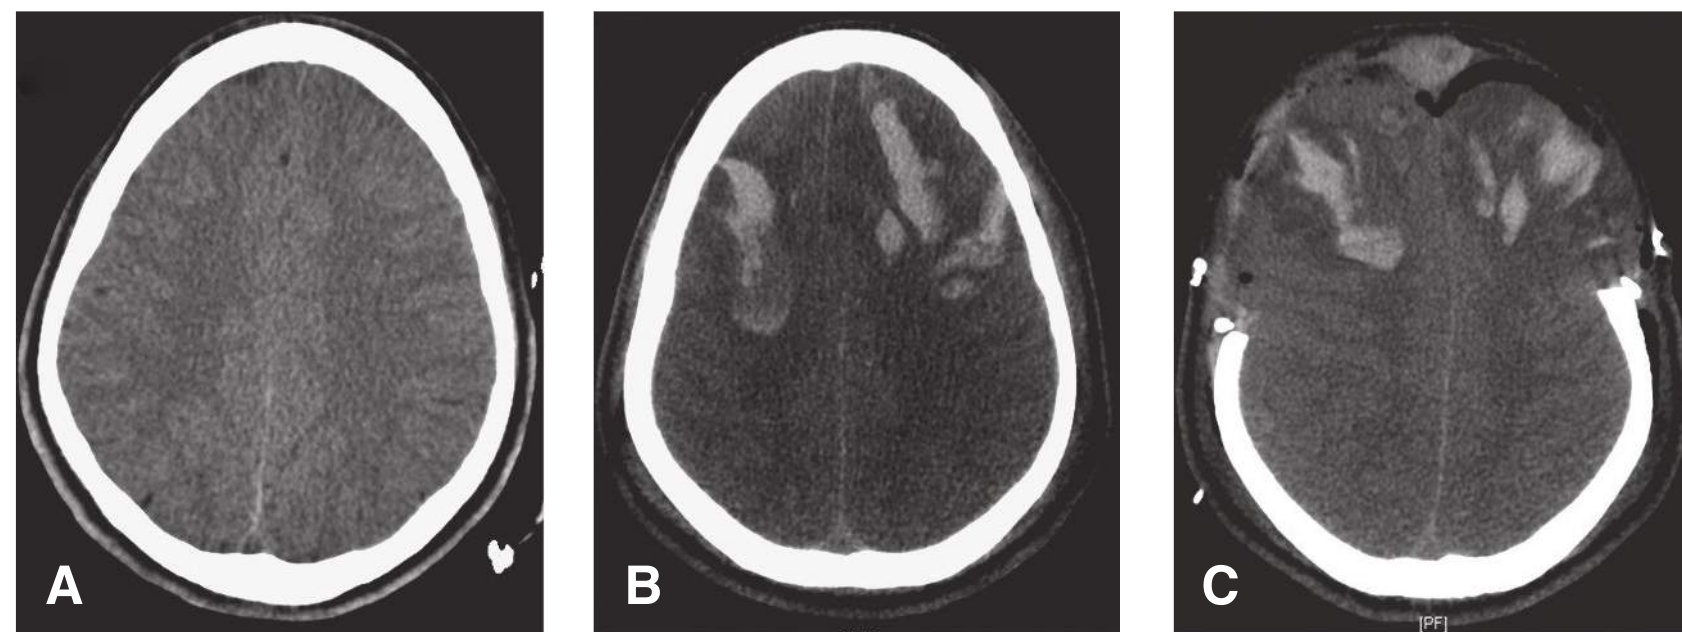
Intracerebral hematoma expansion within bifrontal contusions. This 27-year-old male patient presented with a GCS score of 3 after being ejected head first from a motorcycle during a collision. Initial noncontrast head CT was significant for bilateral frontal lobe contusions with early evidence of sulcal effacement (A). A follow-up noncontrast head CT performed 9 hours after initial presentation showed the interval development of large bilateral intraparenchymal hemorrhages (B). The patient subsequently developed refractory intracranial hypertension necessitating performance of a bilateral frontotemporal craniectomy with duraplasty for ICP control (C).
